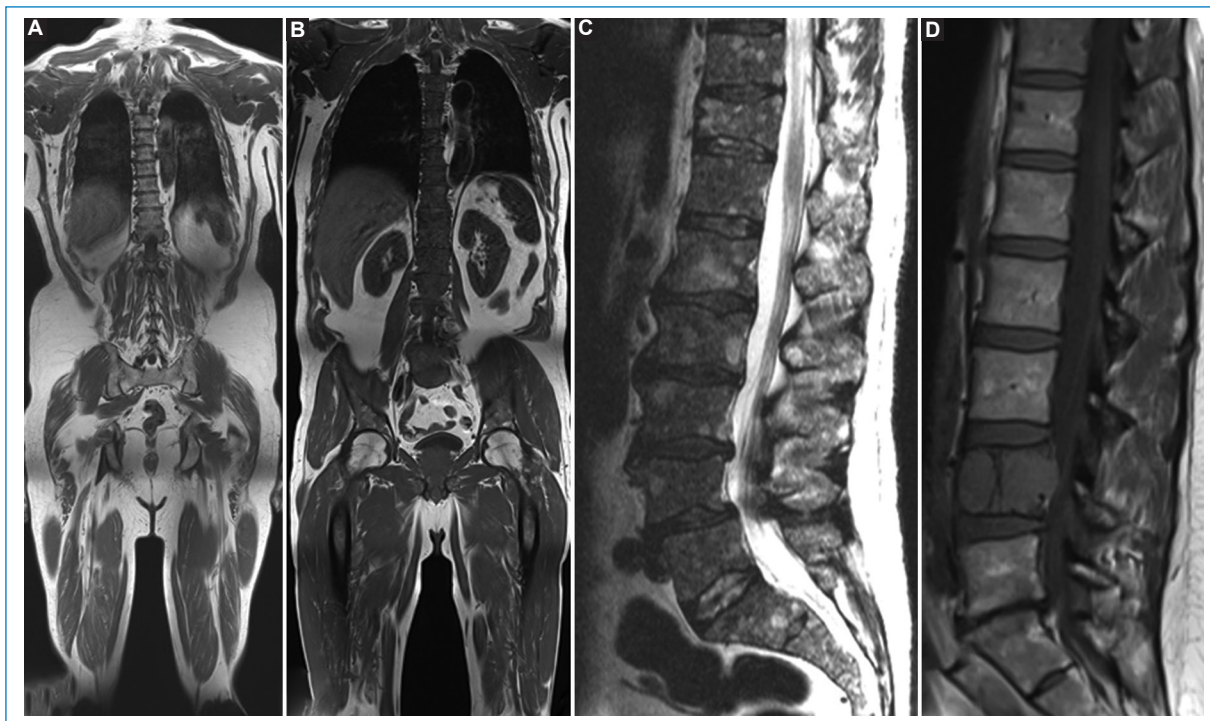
Coronal whole body MRI with T1 hypersignal characteristic of normal fatty bone marrow (A), coronal body MRI with diffuse T1 hyposignal of the spine and pelvis, and normal signal of the femoral heads, in the context of a diffuse infiltrative pattern (B), sagittal T2 MRI of the lumbar spine with heterogeneous “salt and pepper” signal (C) and sagittal T1 MRI of the lumbar spine with an expansile lesion that replaces the L4 vertebral body, hypointense, compatible with plasmacytoma and focal pattern (D).
